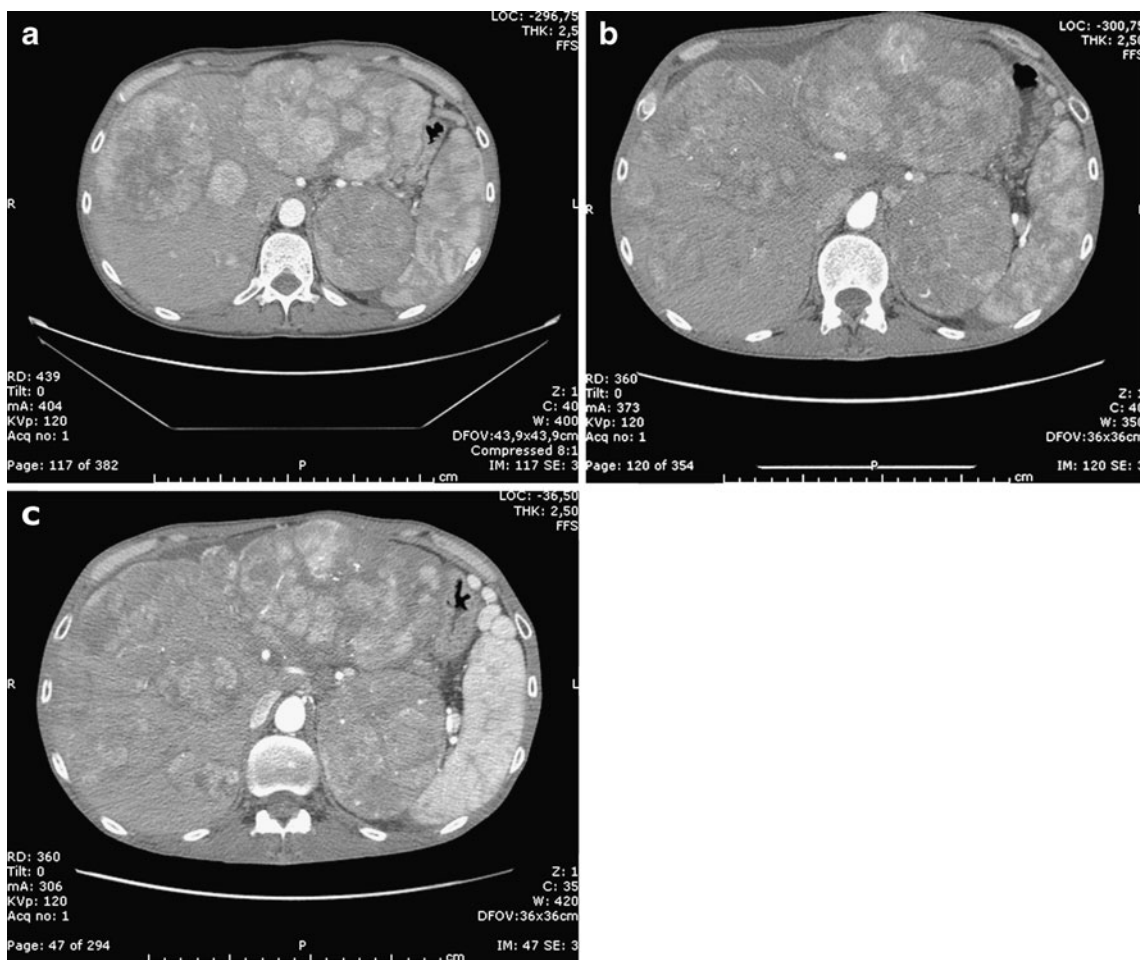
Abdominal CT scans of the numerous lesions in the liver, the largest of which are 14 cm. a Before treatment; b after 3 months on sorafenib therapy, revealing a reduction of arterial enhancement; and c after 6 months on therapy, showing a slight reappearance of arterial enhancement
